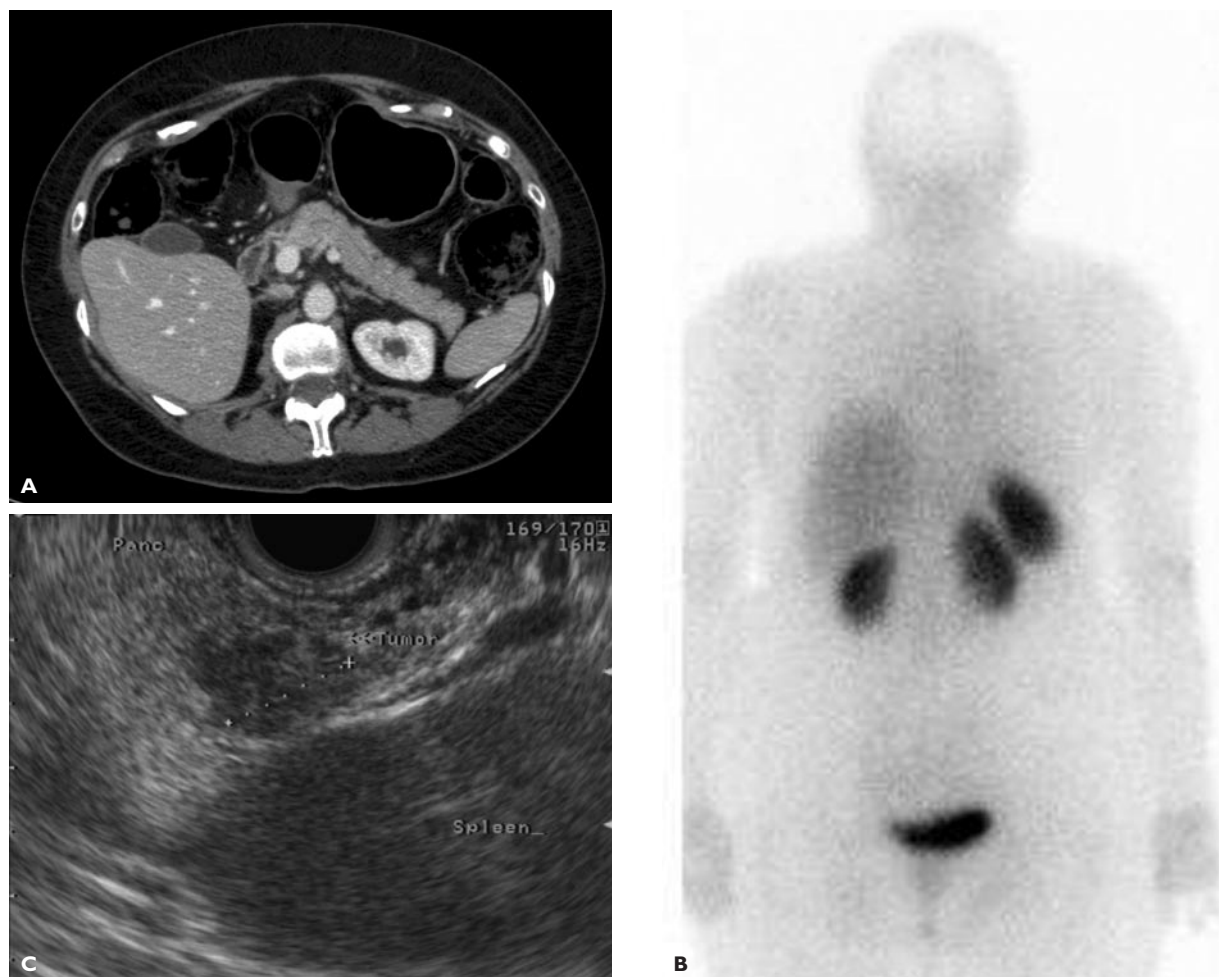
(A) Computed tomography scan in a patient with clinical manifestations suggestive of an insulinoma. No mass lesion is visible in the pancreas. (B) Somatostatin receptor scintigraphy in the same patient. No pathologic lesions were seen; however, normal renal and splenic uptake is noted as well as accumulation in the bladder. (C) Endoscopic ultrasound (EUS) images from the same patient disclose a 1-cm mass lesion in the tail of the pancreas. EUS-guided fine-needle aspiration confirmed insulinoma. (Images courtesy of Dr. David Schwartz, Vanderbilt University, Nashville, TN.)
